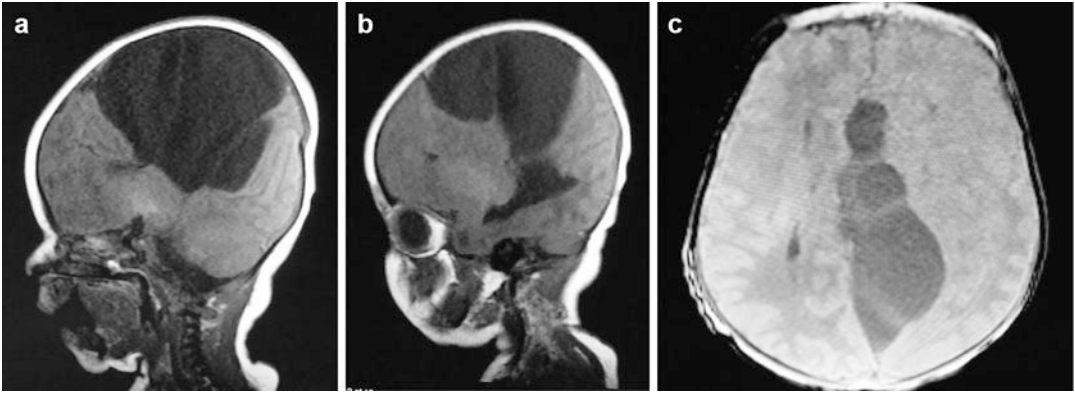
(a–c) MRI of the brain of a neonate showed a large open-lip schizencephaly extending to the *right* convexity causing a large gap in the *right* cerebellar hemisphere. There is also absence of the corpus callosum
